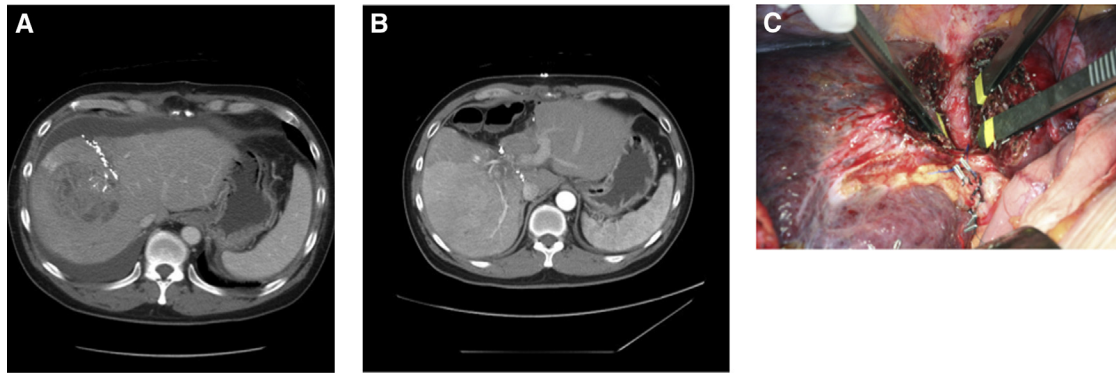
(A) A 51-year-old chronic hepatitis B (HBV) carrier with a solitary 11 cm right lobe hepatocellular carcinoma and future liver remnant/estimated standard liver volume ratio of 24.2%. Computed tomography showed a partially split liver in stage I procedure. The hypertrophied left liver may reduce the transverse distance between the 2 transection surfaces, rendering further transection of the remaining tissue plane in stage II more challenging. (B) A 50-year-old HBV carrier with a solitary 5 cm right lobe hepatocellular carcinoma. Computed tomography of a completely split liver. (C) An operative image of a completely split liver with a future liver remnant/estimated standard liver volume ratio of 19.3%.
